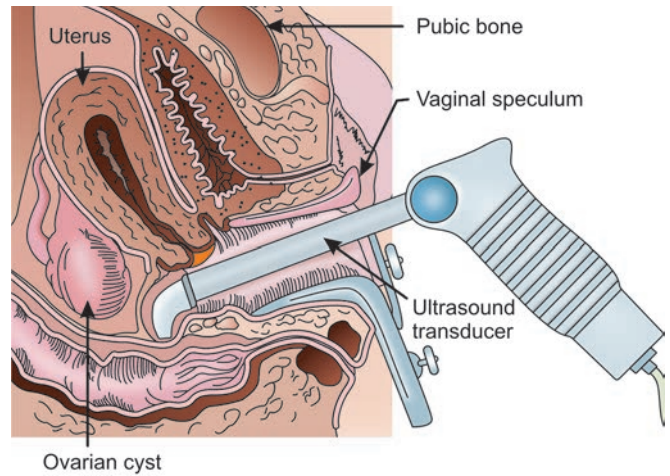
Principle of ultrasound
